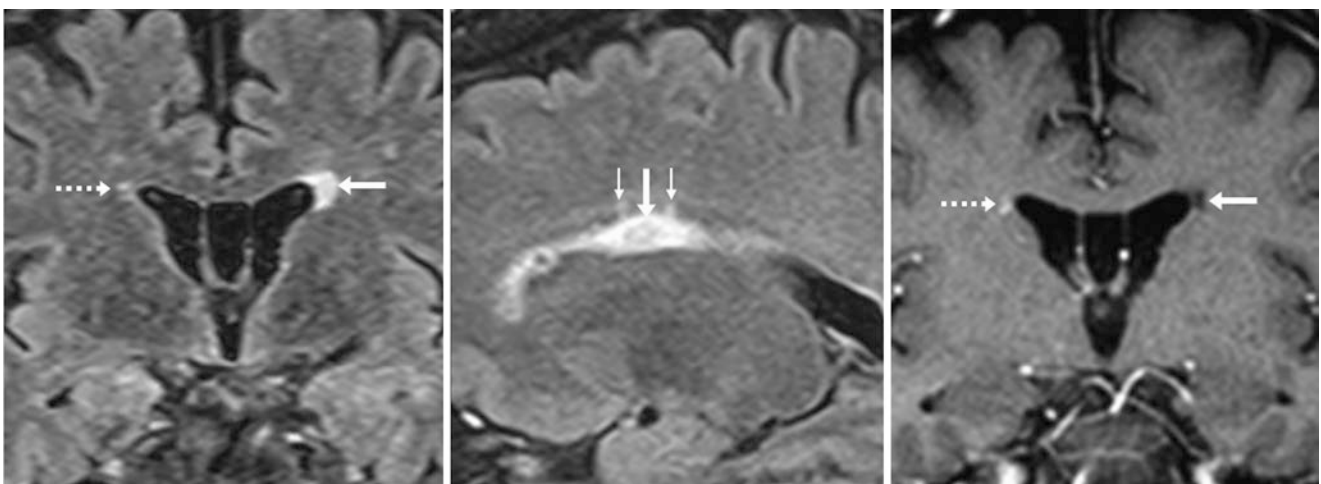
Comparison case of multiple sclerosis. A 49 year old had a demyelinating lesion (*arrows*) noted on the left on coronal FLAIR MRI (*left*), with typical striations (*tiny arrows*) oriented perpendicular to the lateral ventricles on sagittal 2-mm thin FLAIR images (*middle*). The
